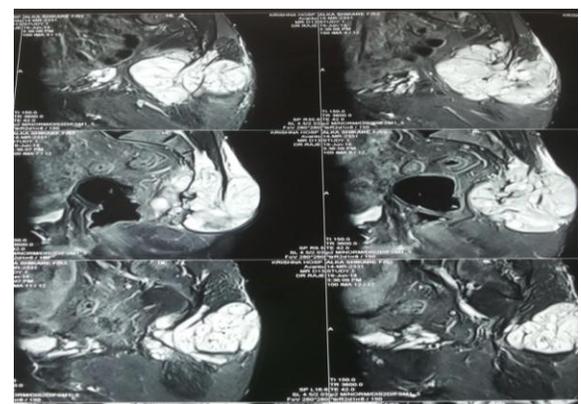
(MRI sagittal section sacrococcygeal region)
